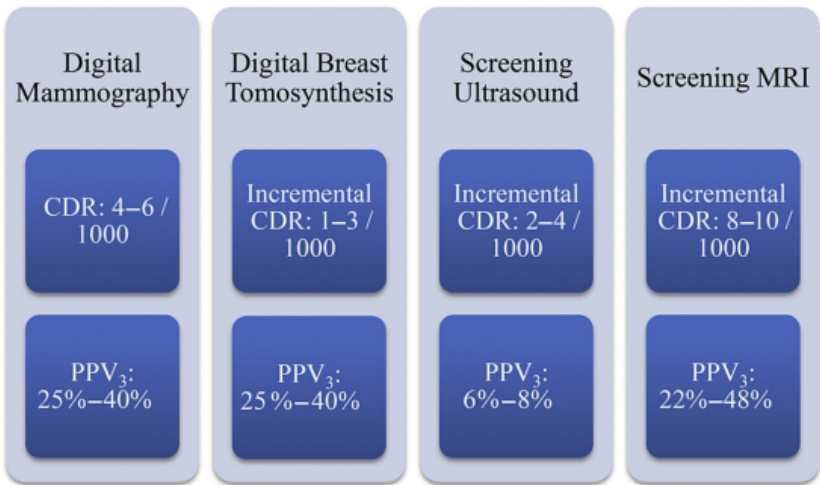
Supplemental screening DBT, ultrasound, and MR imaging incrementally increase cancer detection rate (CDR) when added to digital mammography in women with dense breasts. PPV₃ is the positive predictive value of biopsy and equals the number of cancers detected divided by the number of breast biopsies performed. (Data from Tice JA, Ollendorf DA, Lee JM, et al. The comparative clinical effectiveness and value of supplemental screening tests following negative mammography in women with dense breast tissue. Institute for Clinical and Economic Review; 2013. Available at: <https://icer-review.org/wp-content/uploads/2016/01/ctaf-final-report-dense-breast-imaging-11.04.2013-b.pdf>.)
